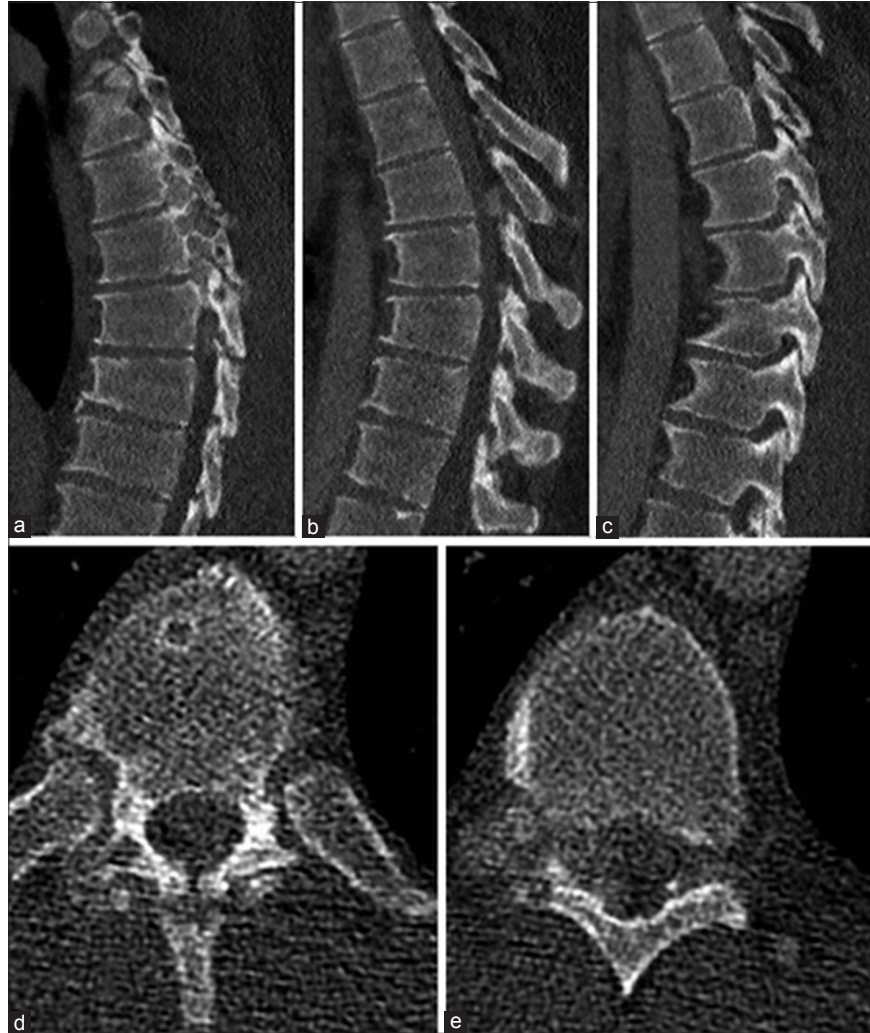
Computed tomography (CT) images showing lytic process of bilateral thoracic facet joints with compression of the spinal cord. (a) Sagittal CT scans of the mid-thoracic spine demonstrating erosive changes of the right facet joints, (b) sagittal STIR sequences, (c) sagittal T1 sequences without contrast, (d) sagittal T1 sequences with contrast, (e) axial T1 magnetic resonance imaging with contrast demonstrating extension of a tophus into the spinal canal and compressing the spinal cord to the left.
